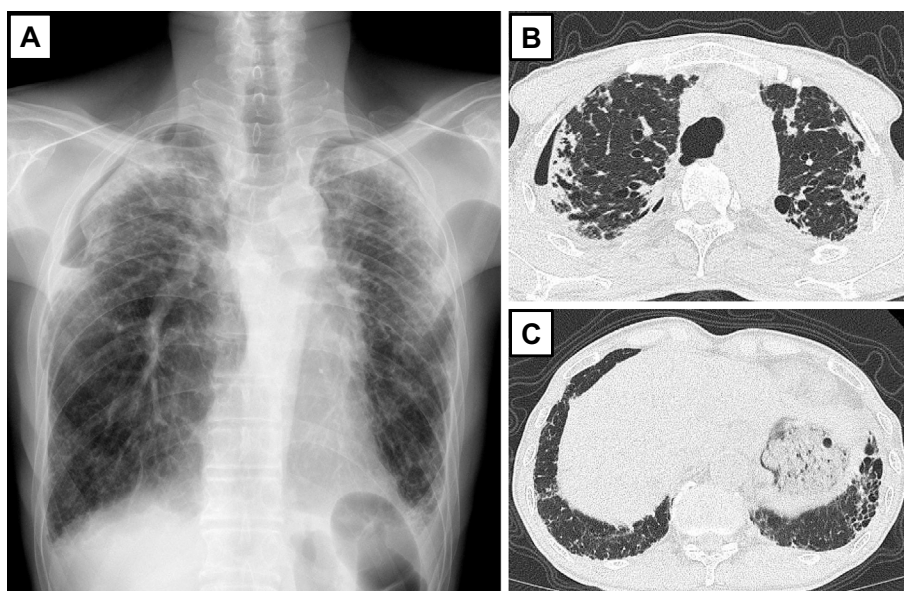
Imaging findings. A: A chest radiograph showed marked apical pleural thickening associated with superior hilar retraction and bilateral pneumothoraces. B, C: HRCT revealed volume loss in the upper lobes, architectural distortion, traction bronchiectasis, and severe pleural and subpleural thickening with fibrotic changes in the marginal parenchyma.
